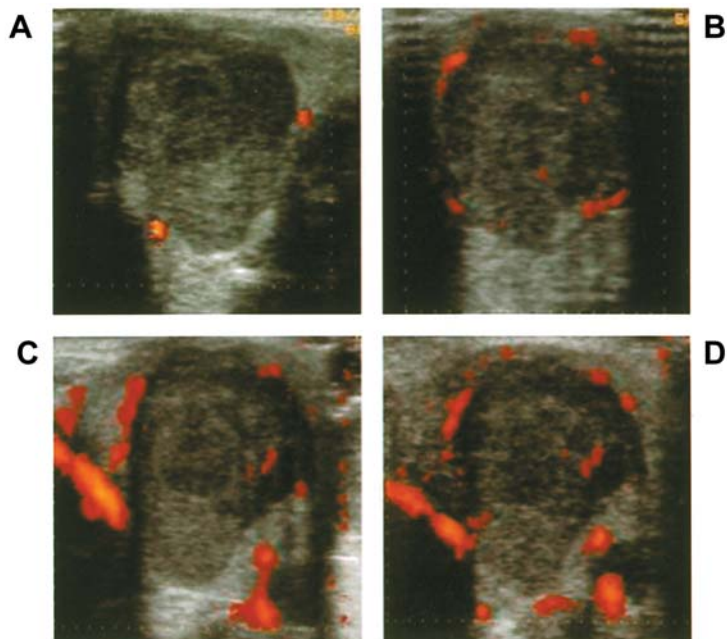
Moderately-differentiated adenocarcinoma. A) Basic color-Doppler: shows single vascular pole. B-C-D) Echo-color-Doppler 30, 60 and 90 seconds after injection of Levovist: marked progressive increase in both intralésional and perilesional vascular signals.*
